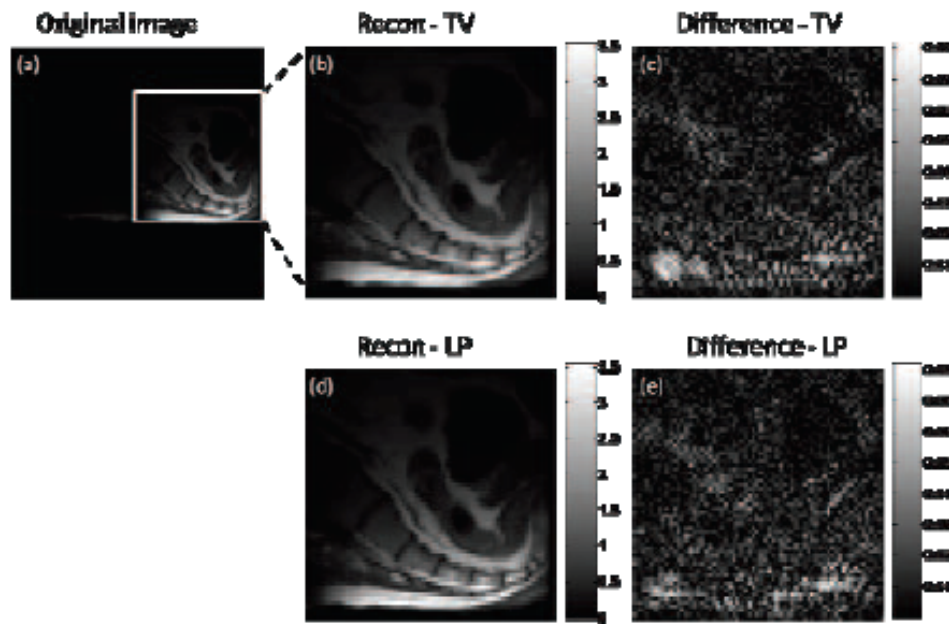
Image reconstruction in the in-vivo MRI spinal array experiment. (a) reference image reconstructed using full k-space data; (b) reconstruction using the TV minimization; (c) the corresponding error image; (d) reconstruction using the LP minimization; and (e) the corresponding reconstruction error image.
